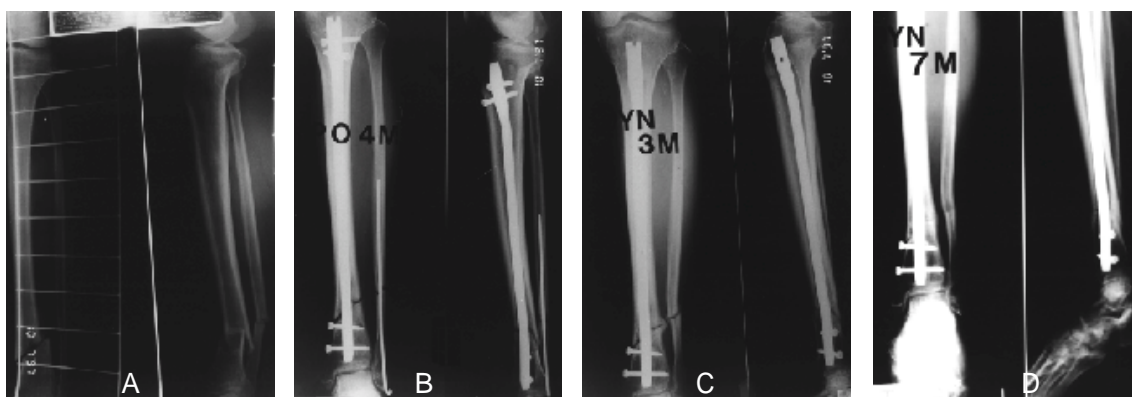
Initial x-ray shows displaced distal tibial fracture.
